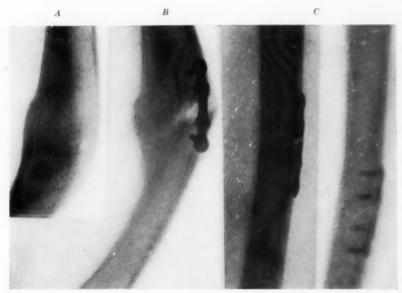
Ununited fracture of femur, due evidently to the Lane plate. A, six months after removal of Lane plate. B, six months after insertion of Lane plate. C, one week after insertion of Lane plate. Taken with portable X-ray.
